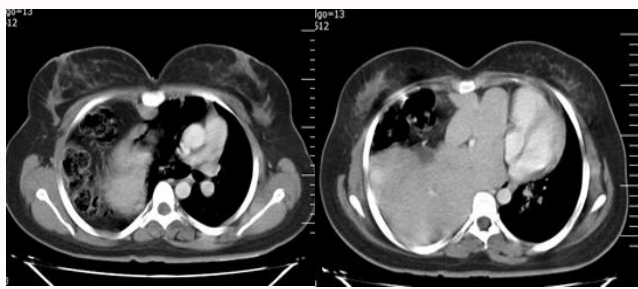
CT-scan of patient show herniation of liver, omentum, colon and intestine in pleural space.
